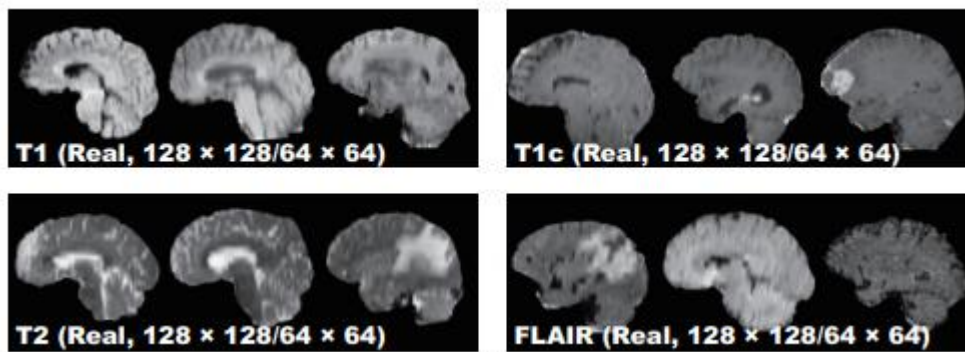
Real MR images for training the GANs
